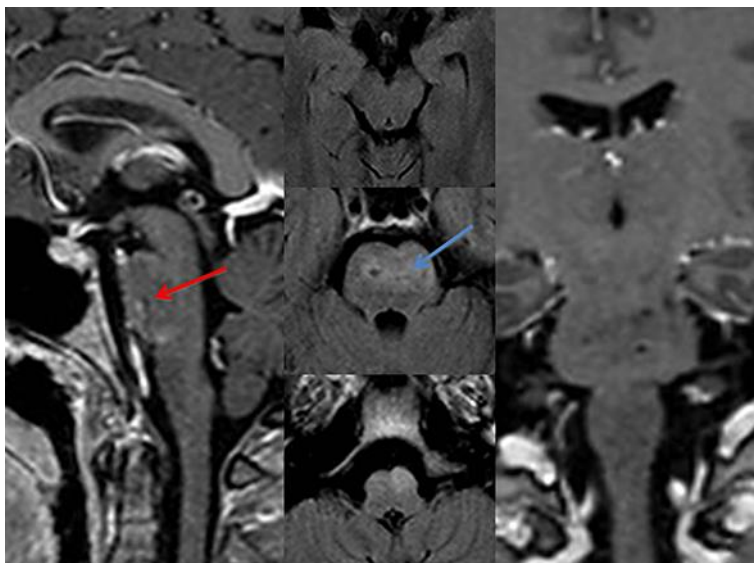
Axial-FLAIR images in the middle column (from top to bottom: midbrain, pons and medulla oblongata) show a radiological improvement with a lower mass effect and the size of the lesion, yet still showing a cystic change (blue arrow). On the other hand, there was an increase of the inferior olivary nucleus. Sagittal (left column) and coronal (right column) post-contrast T1WI show the lesion with dotted enhancement in the pons (red arrow).
